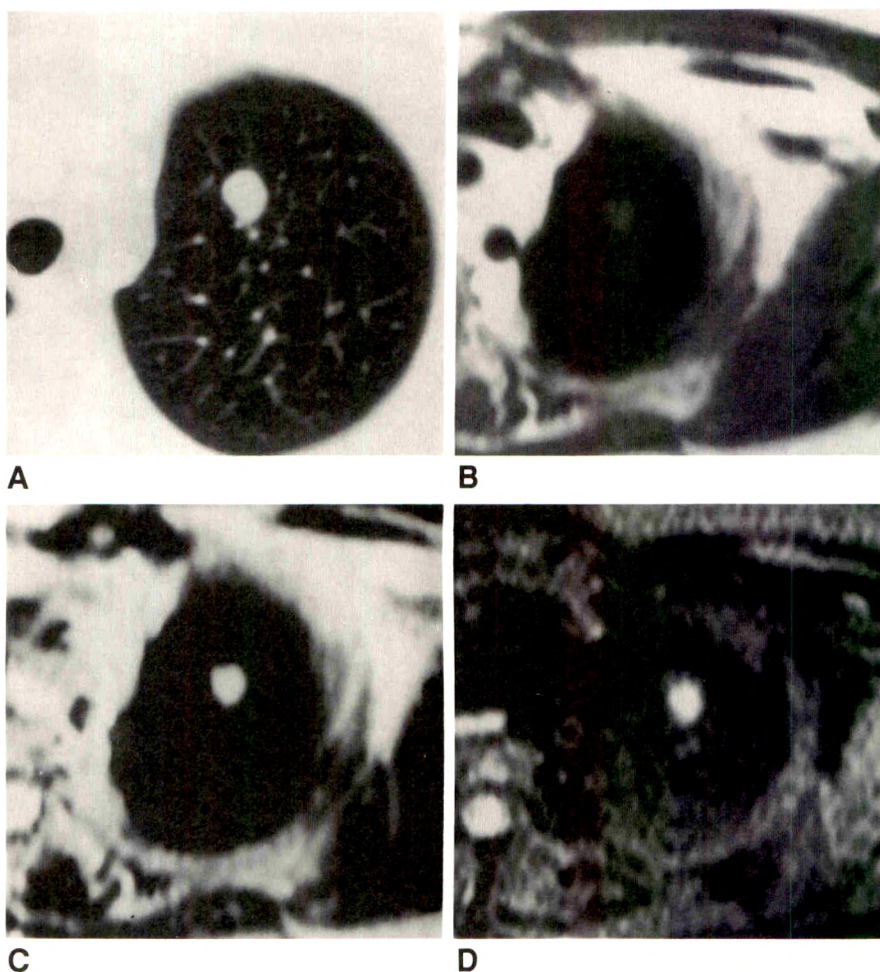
A, CT scan shows bronchial carcinoid tumor of left upper lobe.
